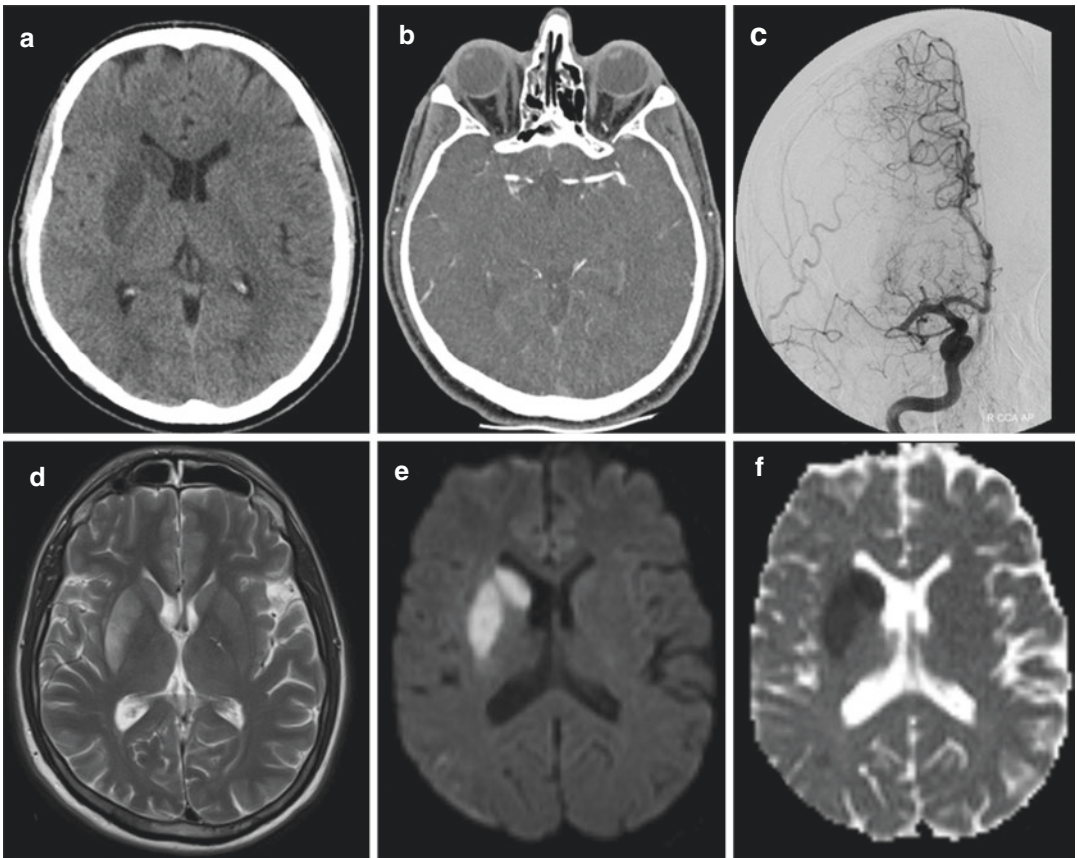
Acute ischemic stroke patient with NCCT, CTA, MRI, and DSA images, (a) NCCT shows parenchymal hypodensity and swelling on the right caudate head and putamen, (b) CTA demonstrates no contrast filling in the right M1 segment related to thrombus and gaze palsy is seen to the pathologic right side, (c) DSA shows no contrast filling in the right M1 segment, (d) swelling and edema are seen on the right caudate head and putamen on T2-weighted image, (e) diffusion restriction on the same region is seen on DWI B1000 image and ADC maps (f)
